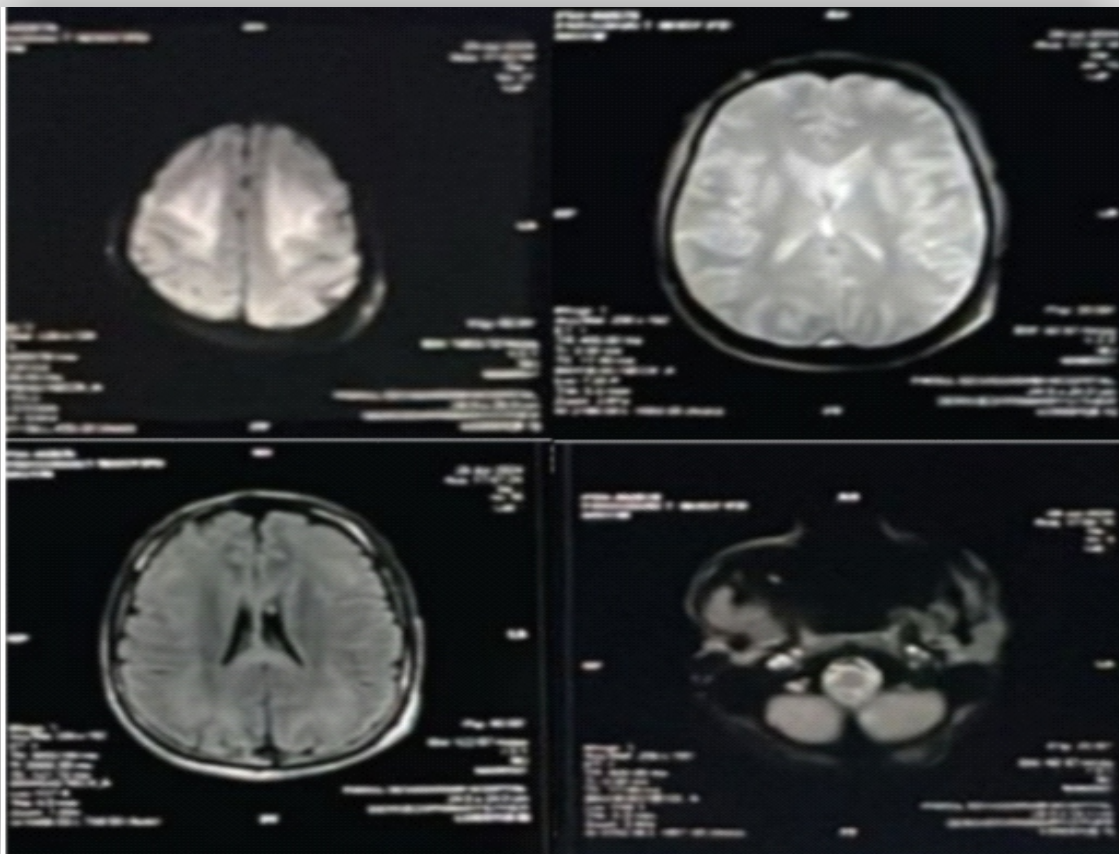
MRI brain (DWI/ADC and T2/FLAIR) demonstrating bilateral, symmetrical confluent diffusion restriction with low ADC and T2/FLAIR hyperintensity involving the frontoparietal-occipital deep white matter and entire corpus callosum, with additional symmetric T2/FLAIR hyperintensity (T2 shine-through) in the dentate nuclei, vestibular nuclei, and inferior colliculi.
